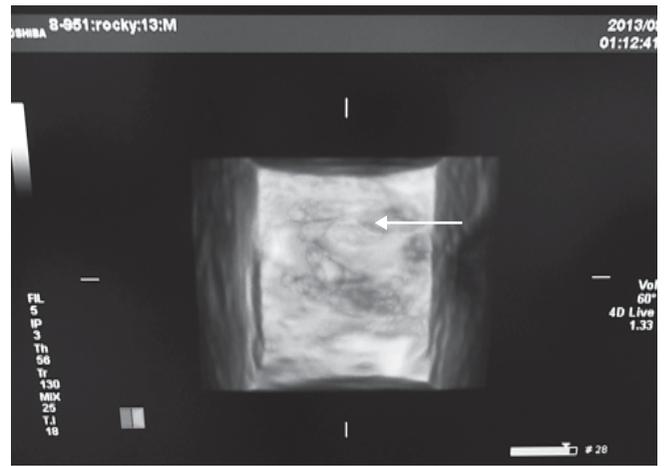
3D ultrasonogram showing enlargement of the prostate gland. The parenchyma and the glandular alveoli of the prostate (arrow) in the fibromuscular meshwork are clearly visible.
